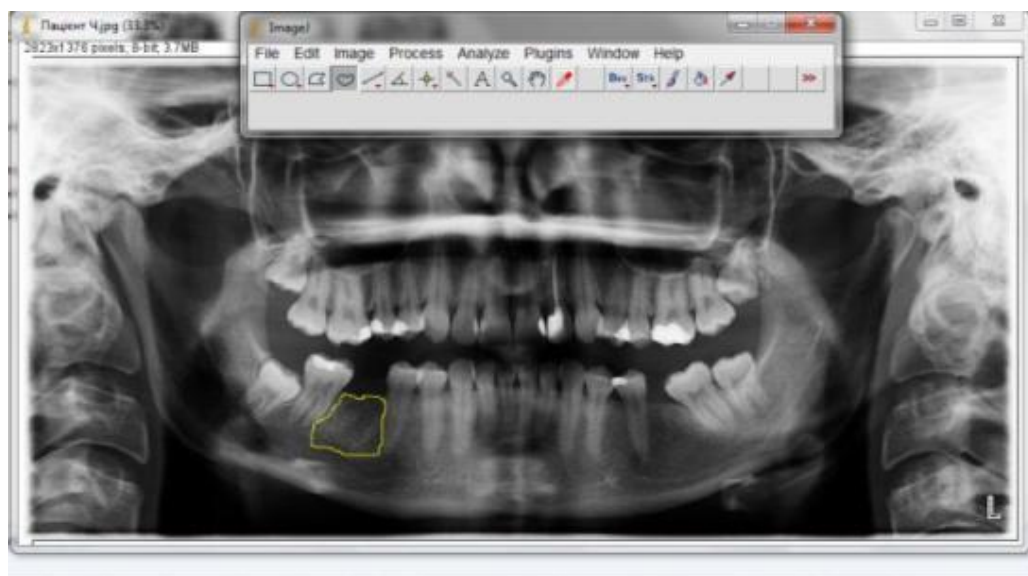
Method for calculating bone tissue density in the molar mesialization area on orthopantomograms according to the method of Geiger M. (2016)
